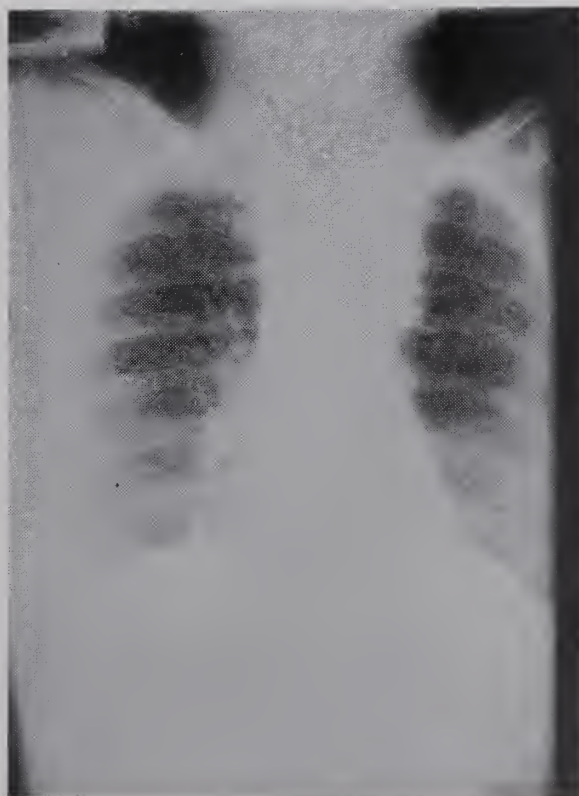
Admit PA Chest Xray.
